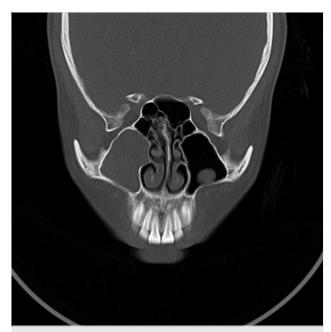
CT image of the paranasal sinuses showing a lesion of soft tissue density occupying the right maxillary sinus CT: computed tomography
